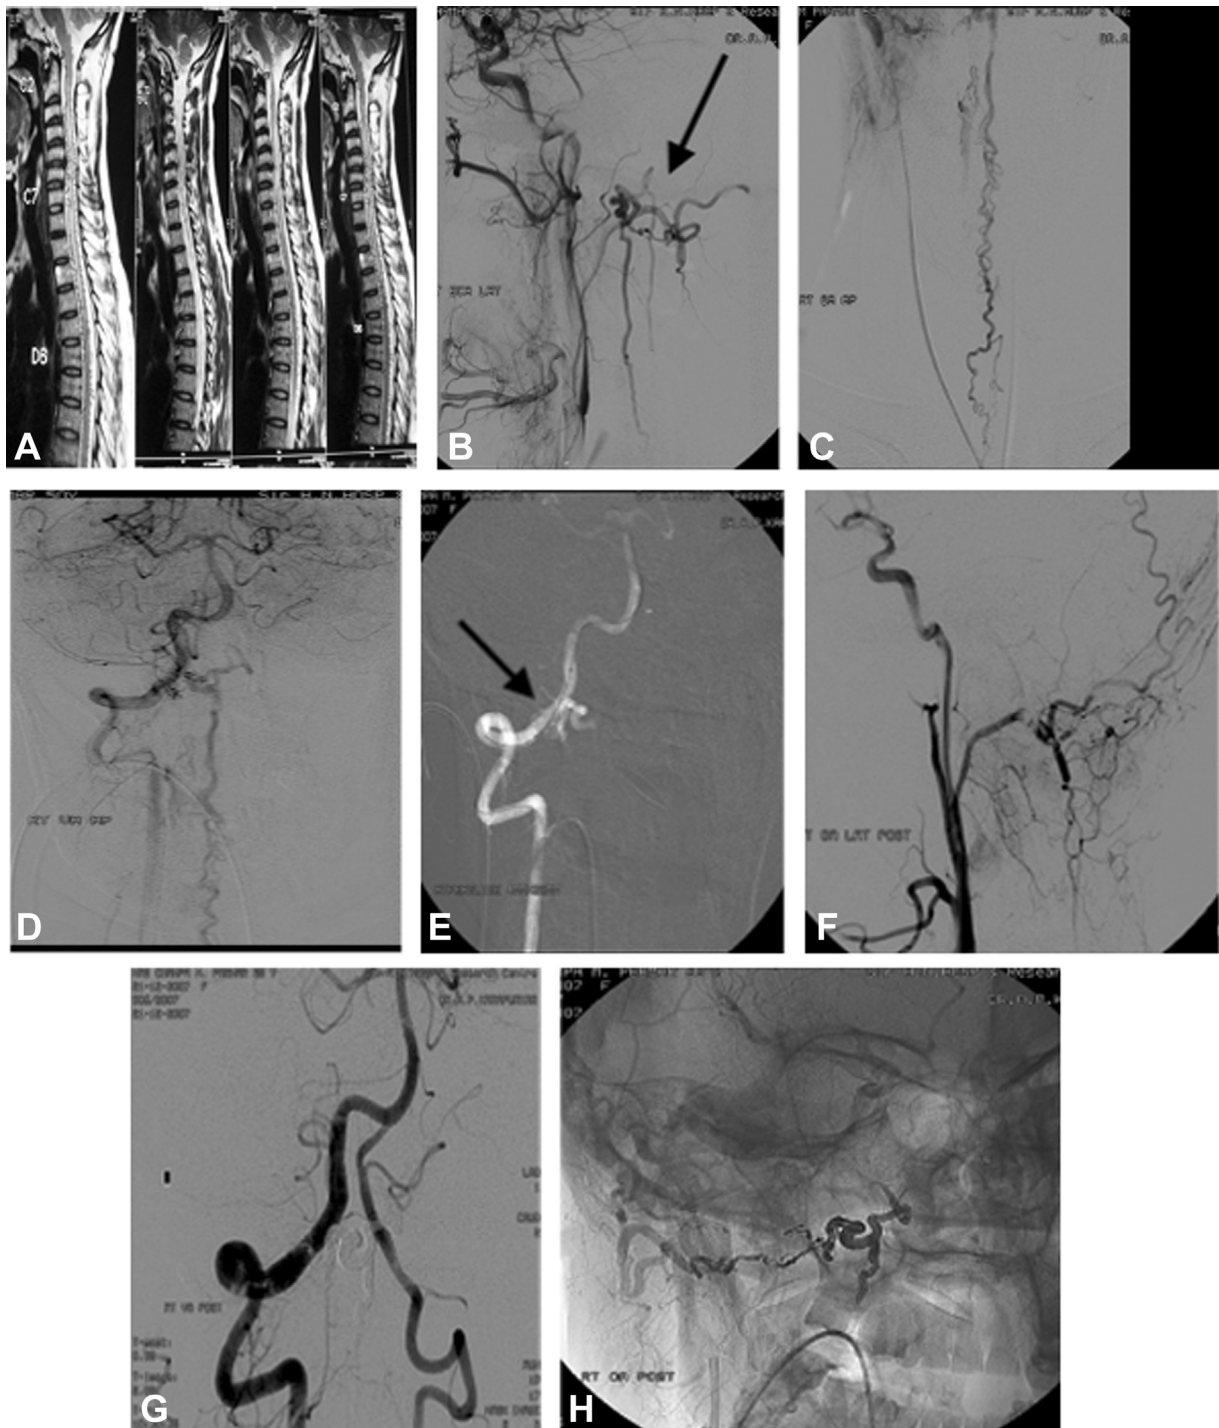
Magnetic resonance imaging T2 (A) showing cervical and dorsal cord edema and abnormal flow voids. (B) External carotid artery angiogram showing a dural arteriovenous fistula, fed by the meningeal branches of the right OA. (C) Angiogram demonstrating drainage by a pair of medullary veins all the way down to the cauda equina. (D) Right vertebral artery angiogram revealing additional feeders from the dural branches of the right vertebral artery at C1 level. (E) A 4 mm × 20 mm HyperGlide balloon inside the vertebral artery at the origin of the feeder (arrow). Post procedure ECA (F) and Vertebral artery angiogram (G) showing complete occlusion of the fistula. (H) Subtracted image showing Onyx cast.
